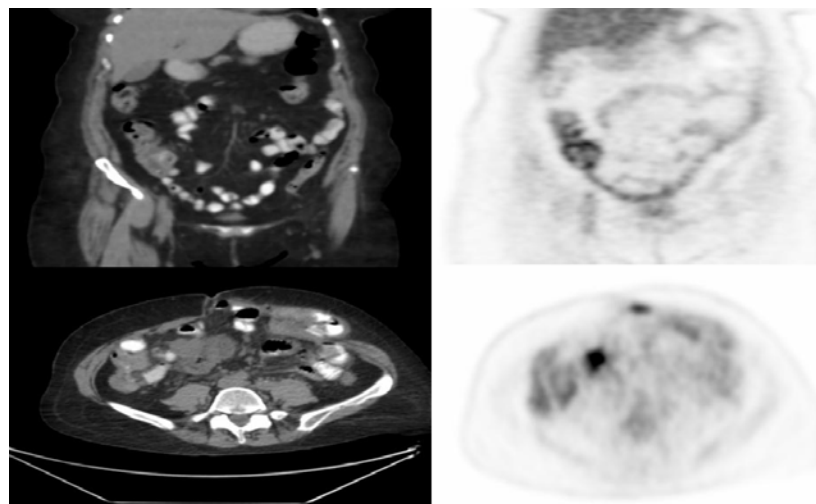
Sixty-four-year-old woman with endometrial cancer with and cecal extension and positive PET results and normal CT scan
